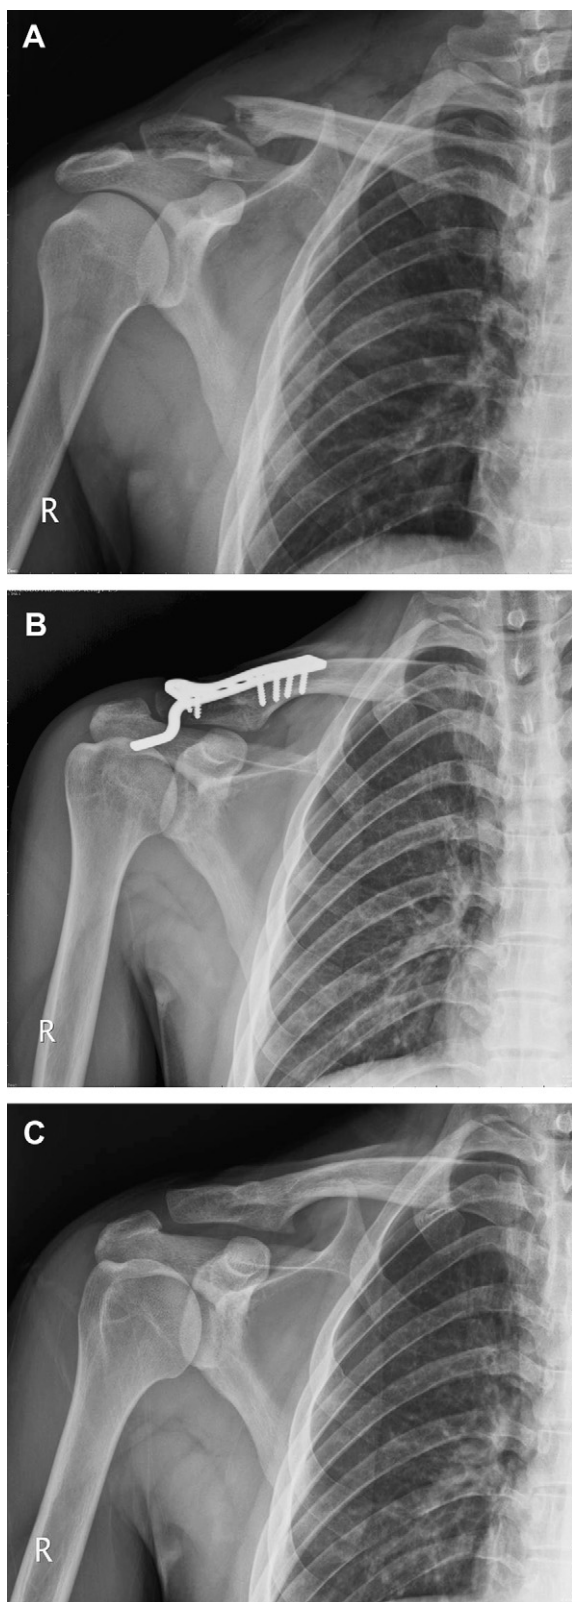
(A) Twenty-six-year-old man with a right distal clavicle fracture caused by an automobile accident. Four fragments are noted over the distal end of the clavicle. (B) Postoperative X-ray showed that Hook plate fixation for Neer Type 2c fracture with adequate fixation and stability. (C) Good bone union (3 months postoperatively) after implant removal.
